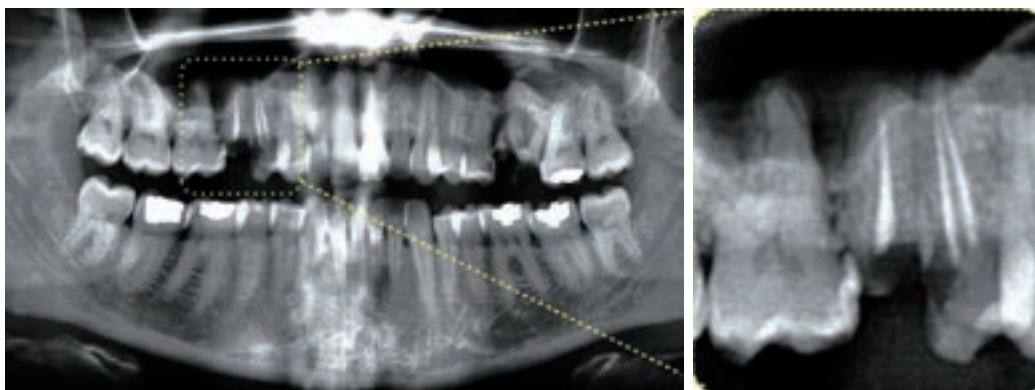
Pre-operative Panoramic Radiograph showing intra-sinus roots
